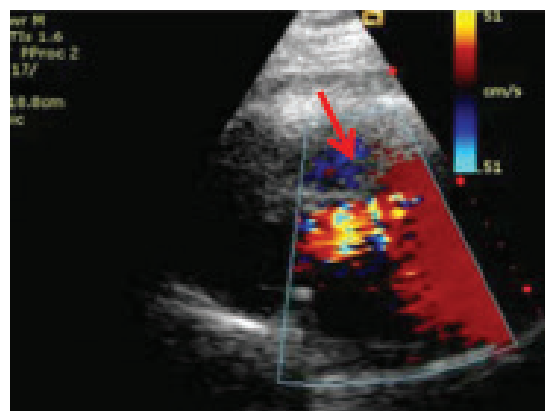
TTE Doppler imaging showing blood flow through the aneurysm.
